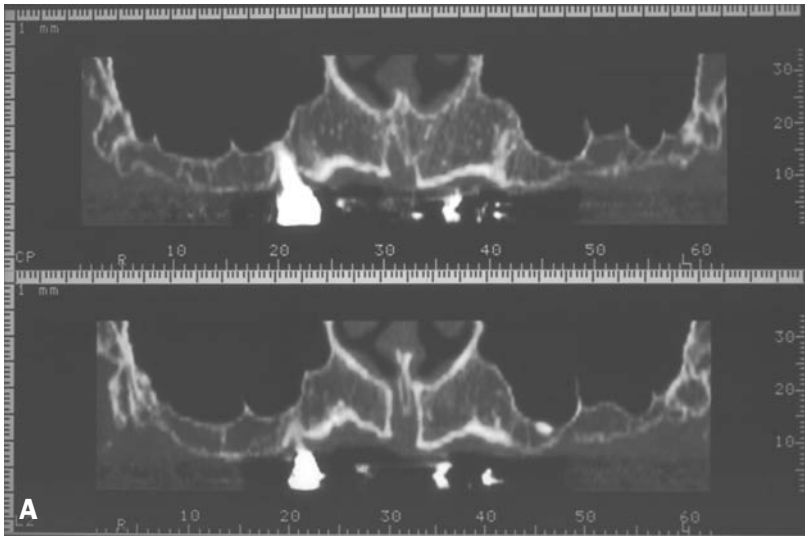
Sinus septae. A, Note small septae in both the right and left sinuses. B to D, Different computed tomographic scan views (panorex, occlusal, and reformatted images) of the same septae that partially and completely run through the sinus. Note the details and differences of the views.
